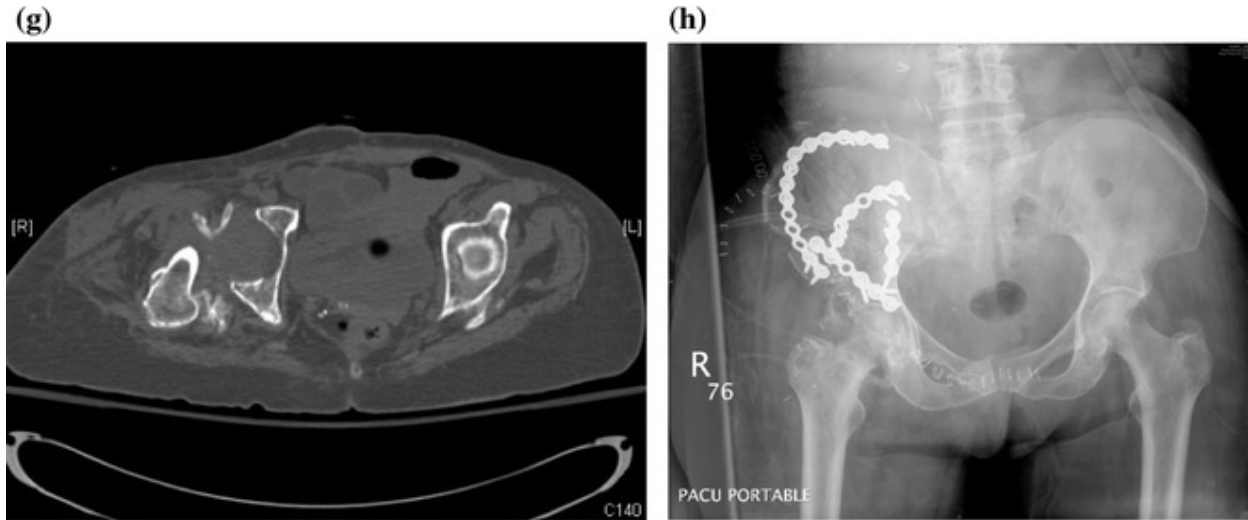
a Anteroposterior (AP) X-ray of the pelvis demonstrates significant lateral displacement of the femoral head. b, c Axial CT scan images demonstrating displacement of iliac wing and dislocation of femoral head. d AP X-ray of the pelvis 3 months postinjury. e–g Axial CT scan images demonstrate extensive callous around the fracture site. h AP X-ray of the pelvis following repair of the nonunion
